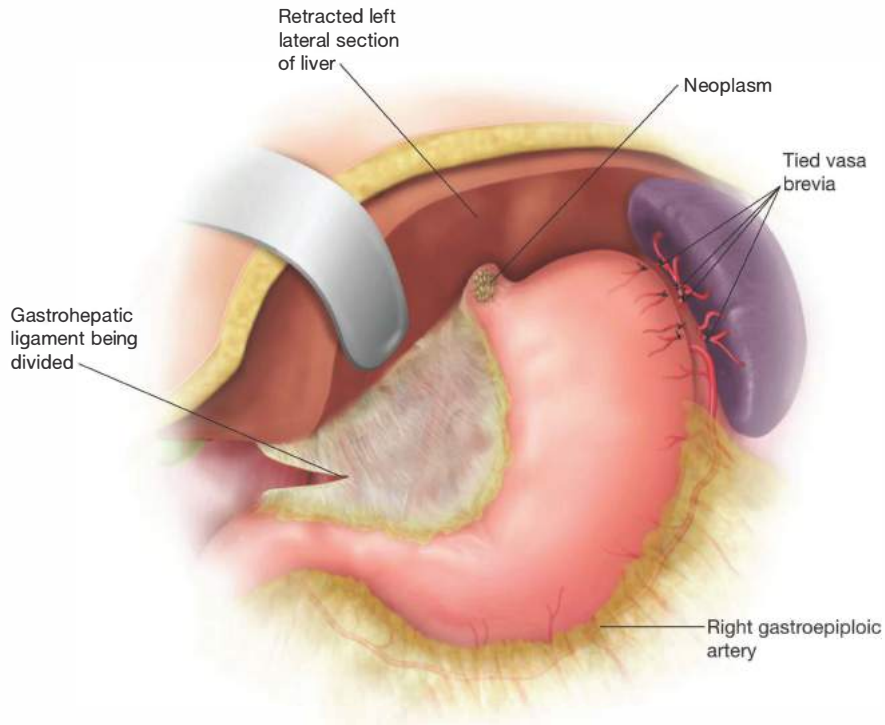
• The lesser curve of the stomach is mobilized. By mobilizing the left lobe of the liver, the left lateral section can be retracted to expose the gastrohepatic ligament. This is also typically avascular. Attention should be given in case there is an accessory or replaced left hepatic artery. This can usually be seen on preoperative contrast CT scans. By opening the gastrohepatic ligament, the diaphragmatic crura can be visualized.
